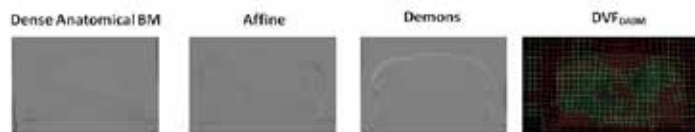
Image Subtraction (CBCT-registered image) for three registration algorithms and deformable vector field for Dense Anatomical Block Matching (DVFDABM).
